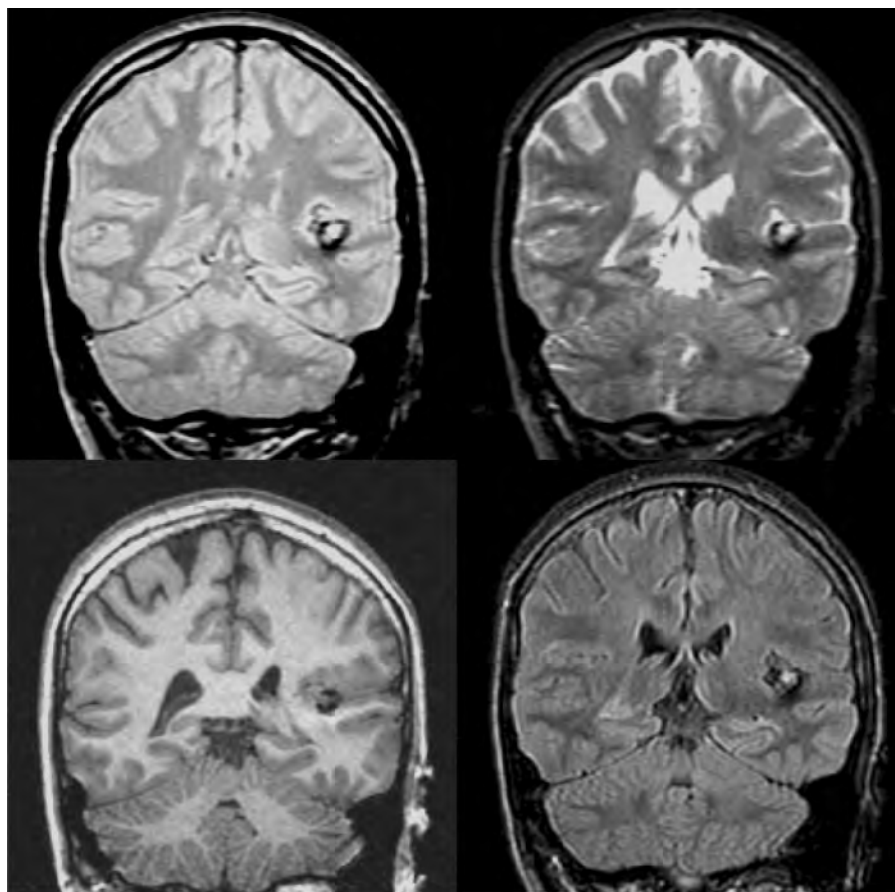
Cavernoma on the left (coronal 3.0 T MRI). Proton density (top L), T2-weighted (top R), IR_{prep} T1-weighted (low L), FLAIR (low R). The acquisitions demonstrate heterogeneous hyperintense signal caused by blood products in different stages of evolution, surrounded by a rim of low signal intensity from haemosiderin.
